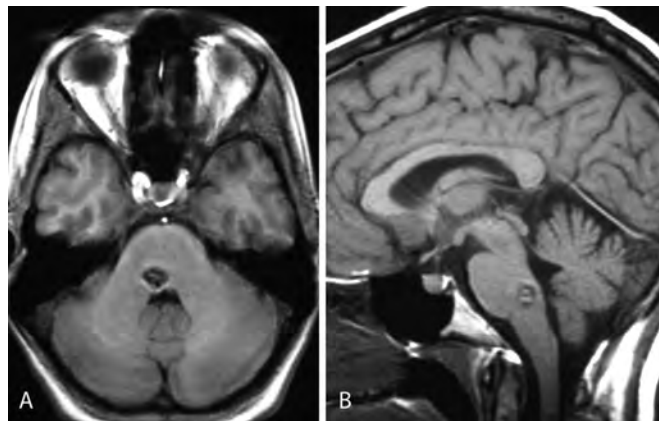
An axial T2 fluid-attenuated inversion recovery (A) and a sagittal T1-weighted image (B) show the pontomedullary CMB significantly reduced in size, making only slight contact with the fourth ventricle and showing less surrounding edema than in previous images.
